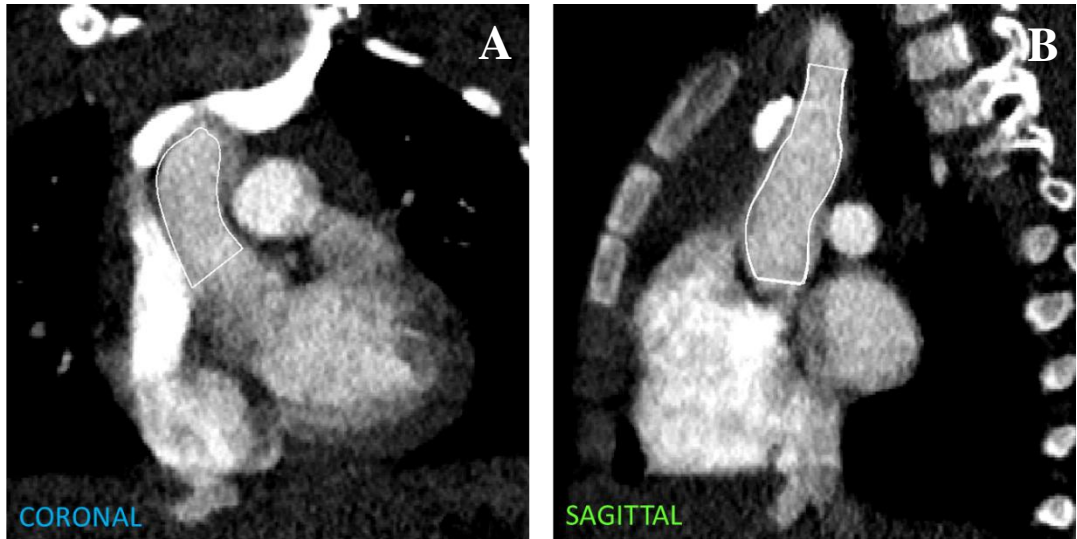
Superposition of the ascending aorta segmented surface onto the CTA images showing the inlet boundary from both the sagittal and coronal view.
